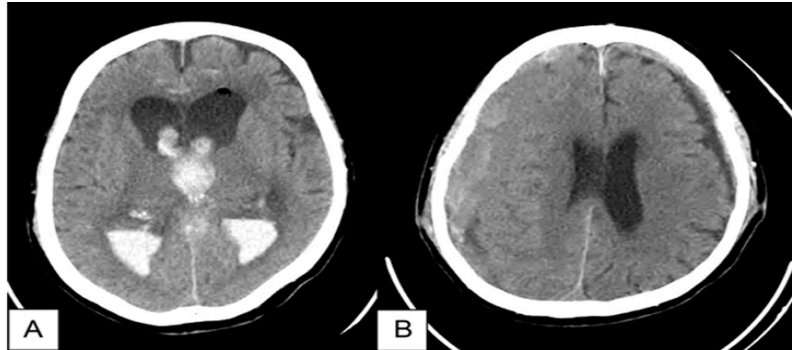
CT brain scan of patient shows: A) Intraventricular hemorrhage bleed in to 3rd ventricle, B) Demonstrates isodensity of subacute right subdural hematoma and chronic hypodense of left subdural hematoma
